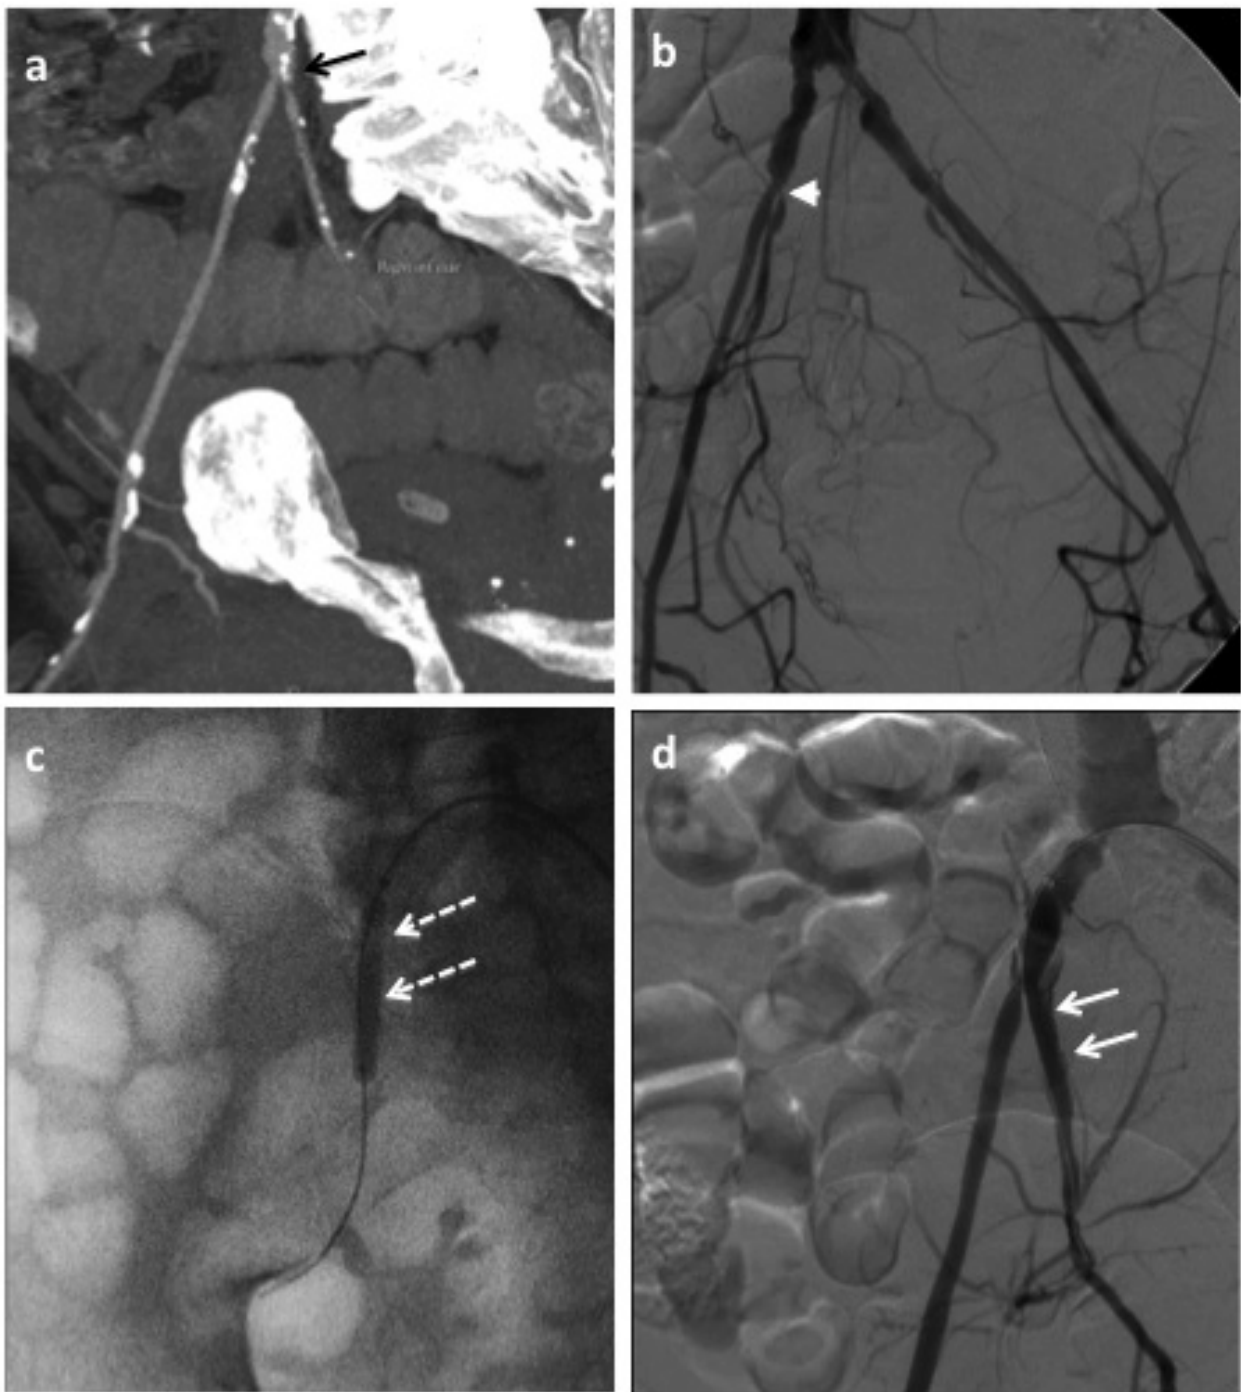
Endovascular techniques for pressure sores in a 54-year-old man with a longstanding SCI and a nonhealing ischial pressure ulcer. (a) Coronal oblique maximum intensity projection (MIP) CT image shows calcified plaque (*black arrow*). (b) Diagnostic subtraction angiogram performed via a right common femoral artery puncture confirms stenosis at the origins of both internal iliac arteries (*white arrowhead*). (c) Balloon inflation is shown across right internal iliac artery stenosis (*white dashed arrows*). (d) Diagnostic subtraction angiogram post balloon inflation shows improvement of internal iliac artery lumen (*white arrows*). There was good angiographic result post stenosis dilation.
